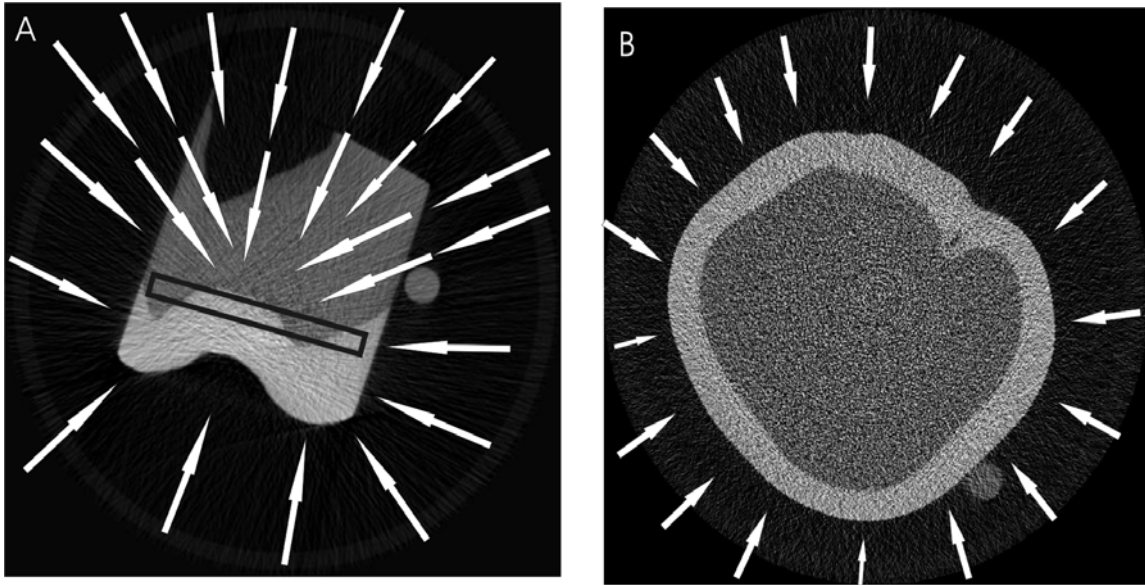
Image of a reconstructed slice showing the influence of dense areas on the results. “A” represents G2 and visualizes how beams easily reach enamel, even at its internal area (black rectangle). In “B” (G1) it is visualized that the beam has more difficulty to go through the whole sample due to a mantle of enamel, which is very dense and attenuates the X-ray more than dentin. The circle-shaped structure besides the tooth is a 1-mm pure aluminium wire.
